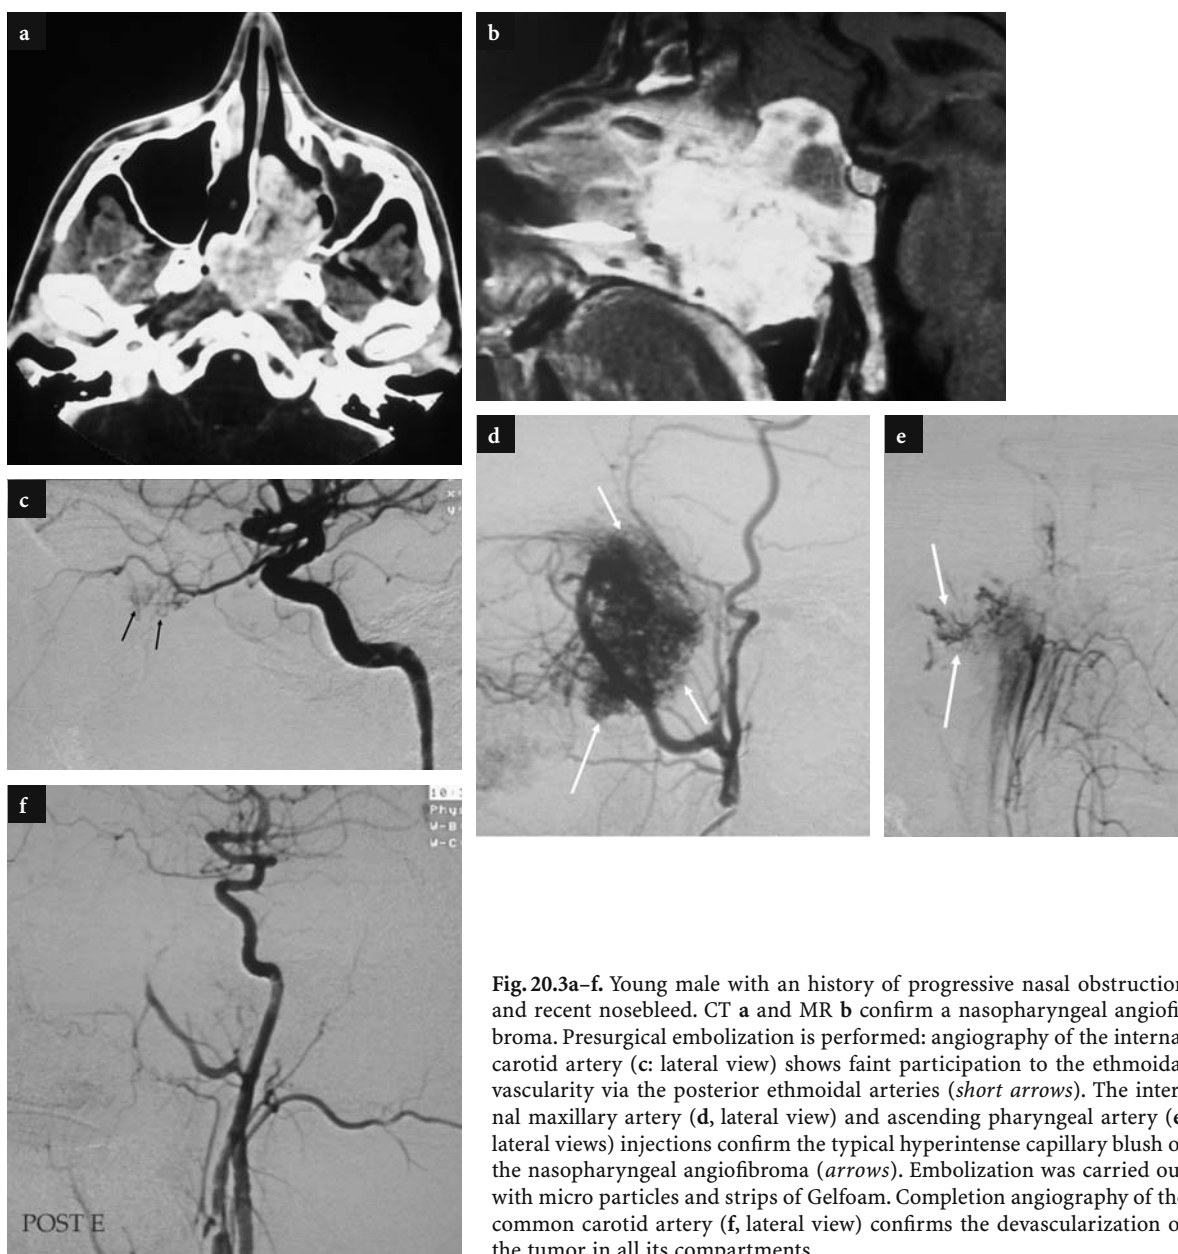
Young male with an history of progressive nasal obstruction and recent nosebleed. CT a and MR b confirm a nasopharyngeal angiofibroma. Presurgical embolization is performed: angiography of the internal carotid artery (c: lateral view) shows faint participation to the ethmoidal vascularity via the posterior ethmoidal arteries (*short arrows*). The internal maxillary artery (d, lateral view) and ascending pharyngeal artery (e, lateral views) injections confirm the typical hyperintense capillary blush of the nasopharyngeal angiofibroma (*arrows*). Embolization was carried out with micro particles and strips of Gelfoam. Completion angiography of the common carotid artery (f, lateral view) confirms the devascularization of the tumor in all its compartments
